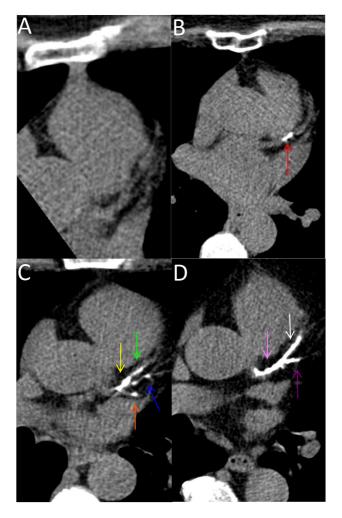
Coronary artery calcium imaged by cardiac computed tomography without contrast in a participant from the pilot SCAPIS study. Cross-sectional view at the level of left main coronary artery and its branches, the left anterior descending artery (LAD) and left circumflex artery (LcX). A: CACS=0; B: CACS=100, red arrow shows calcified plaque in LAD; C: CACS=250, moderate coronary artery calcium, arrows indicate calcified plaques along left main coronary artery and proximal LAD (yellow arrow), mid-LAD (green arrow), LcX (orange arrow), and diagonal artery (DA) (blue arrow); D: CACS=750, severe coronary artery calcium, calcification along the proximal LAD (pink arrow), mid-LAD (white arrow), and DA (purple arrow).
